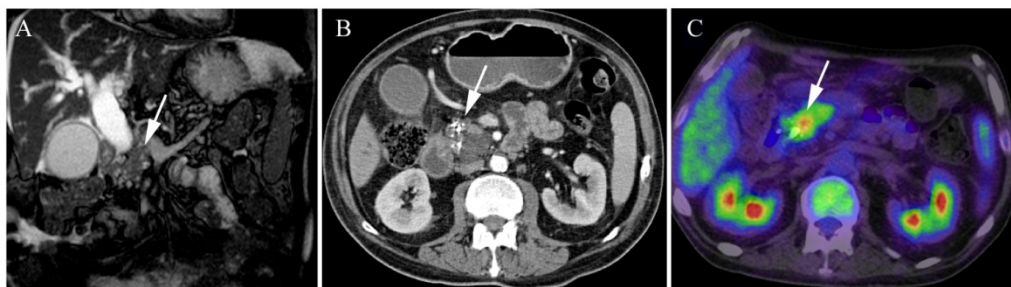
A representative patient with malignant cystic lesion of pancreas seen on [^{18}F]FDG PET/CT: A 56-year-old man, who had been treated for diabetes and had had excessive alcohol consumption for several decades. He developed jaundice, and suspected malignant stricture was observed on ERCP. Serum tumor markers (CA19-9, CEA) were normal. Several cystic lesions were seen in head of pancreas on MRI (arrow) (A) and also calcification on MDCT (arrow) (B). Both MRI and MDCT findings were considered to be caused by pancreatitis. Instead, [^{18}F]FDG PET/CT showed focal uptake in head of pancreas (arrow) (C). Physical condition of the patient was very poor, and therefore operation was not possible. He died 14 months later, and autopsy verified pancreatic adenocarcinoma grade 2, as well as metastatic lesions in liver (Figure adopted from publication III).
